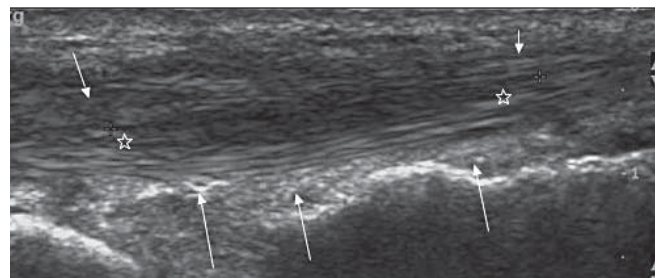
Longitudinal section through a thickened peroneus brevis with a grainy insubstance split. Hypervascularity was seen on colour Doppler.
